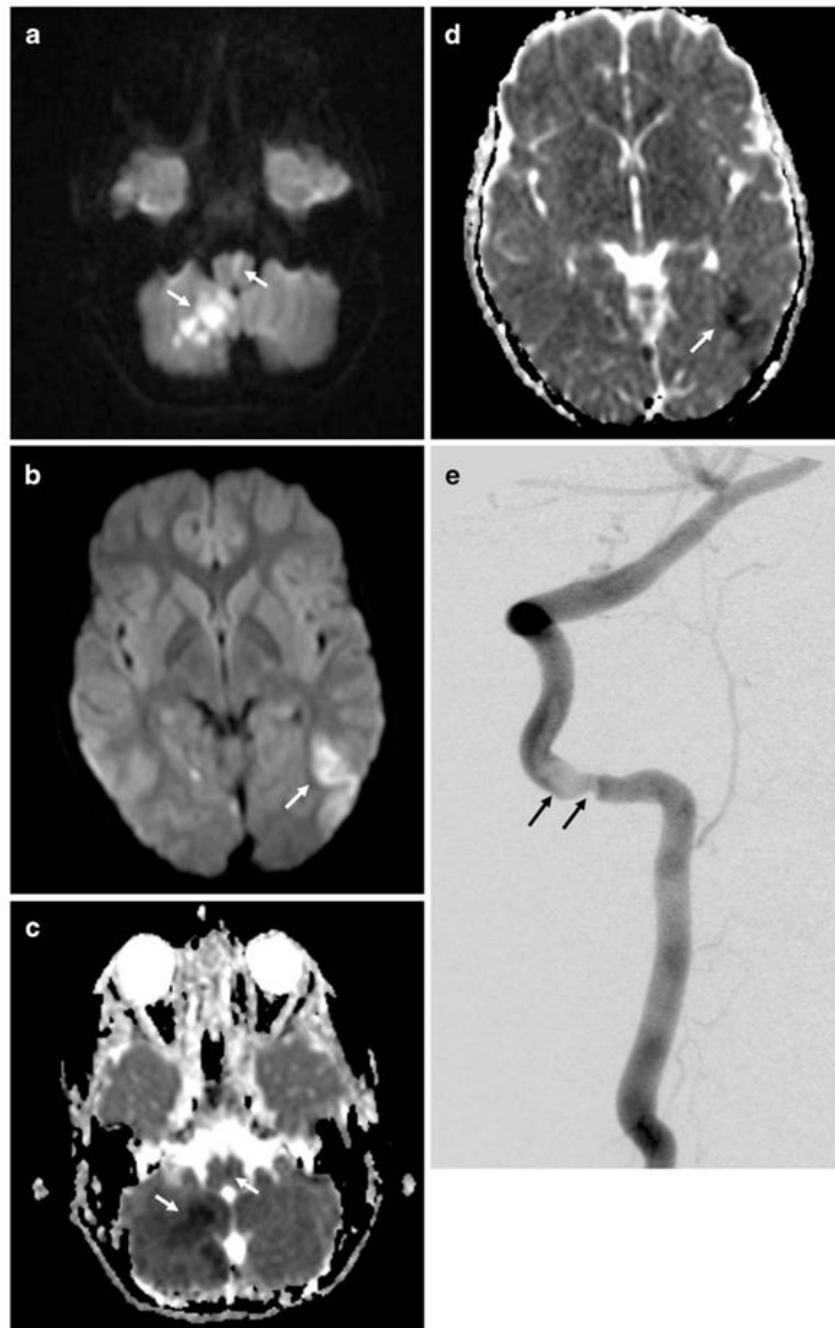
For case 3, diffusion-weighted MRI shows restricted diffusion in the right cerebellum, left medial medulla (a) and left posterior parietal lobe (b) with corresponding dark signal on apparent-diffusion coefficient images (c and d). *White arrows* indicate lesion sites. In e, digital subtraction angiography shows a right vertebral artery dissection with intraluminal clot (*black arrow*)
